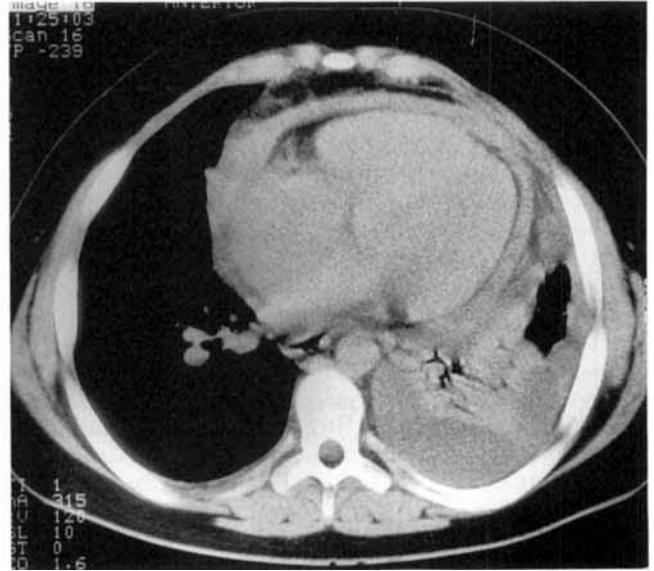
CT scan showing pericardial thickening and large serous effusion.
